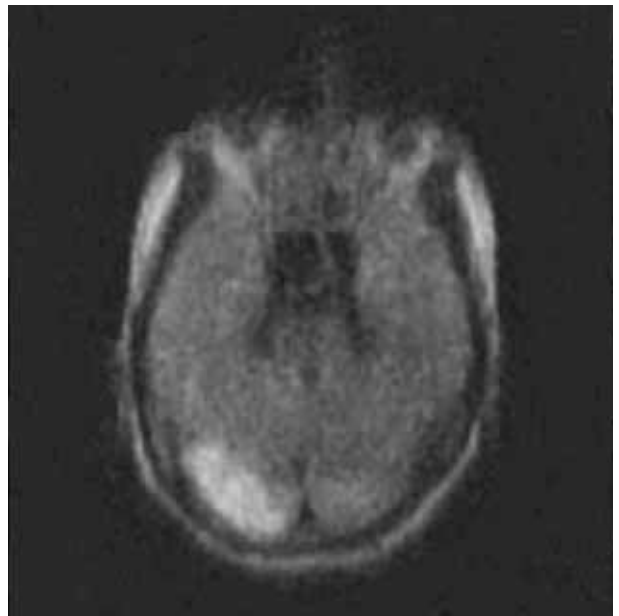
MRI diffusion-weighted image – restricted diffusion in the right occipital lobe.
